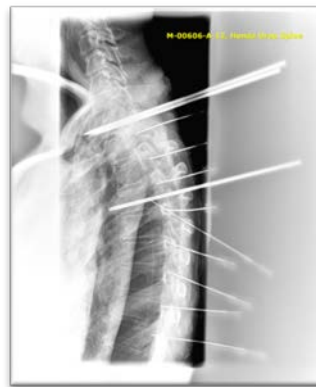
A static X-ray image of subject 582 during instrumentation of the thoracic spine.
